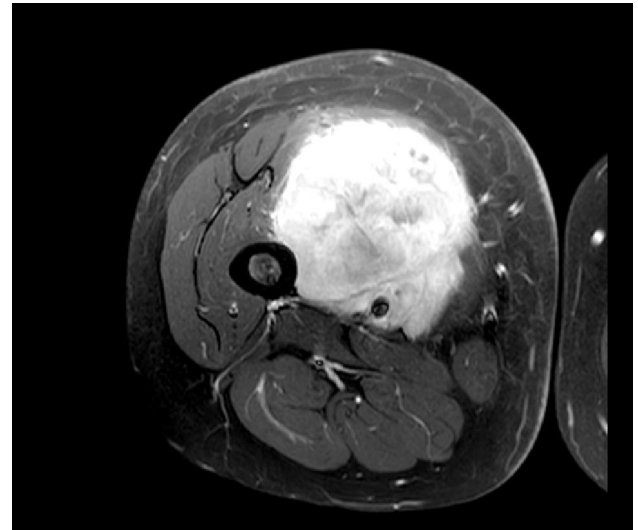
MRI axial T1 post contrast showing large heterogeneously enhancing mass involving the vastus medialis muscle in anteromedial aspect of right thigh; Note the tumor is completely encasing the adjacent femoral vessels and nerve and is closely applied to medial surface of femur with intact cortex.
